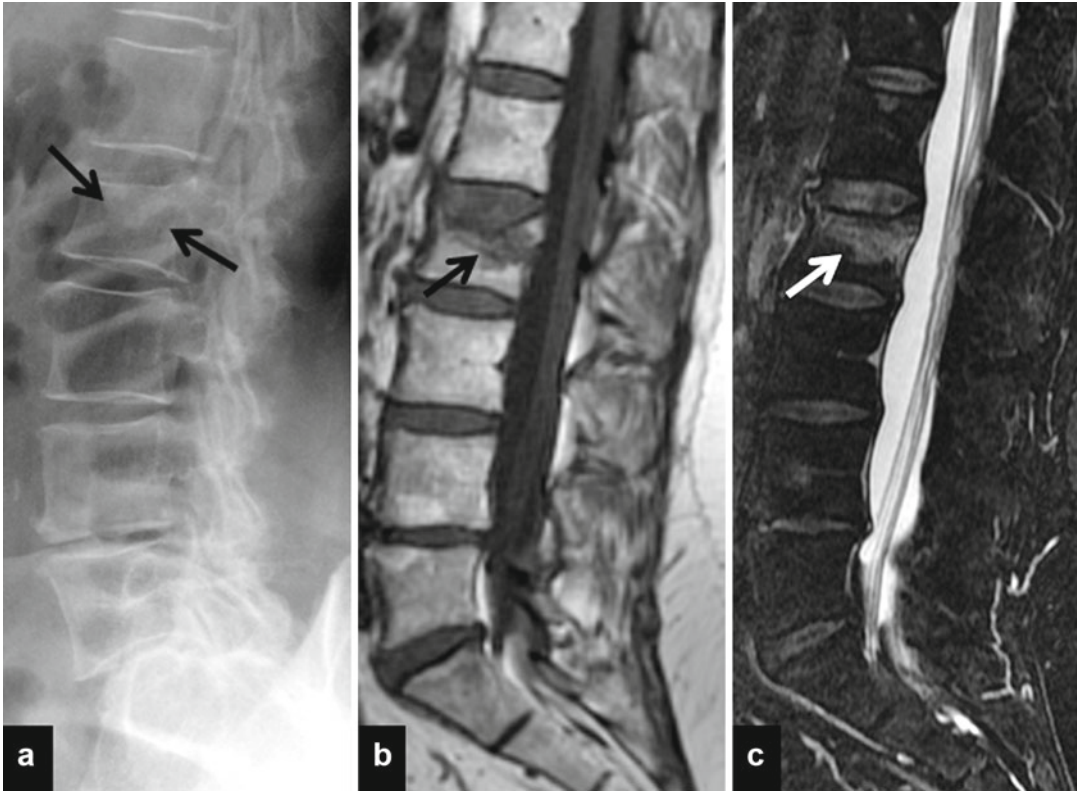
Vertebral fractures in osteoporotic patients. (a) X-ray examination shows the deformation of the vertebral body, with a reduction in height of the front wall. It is also possible to identify the fracture indicated by *two black*
